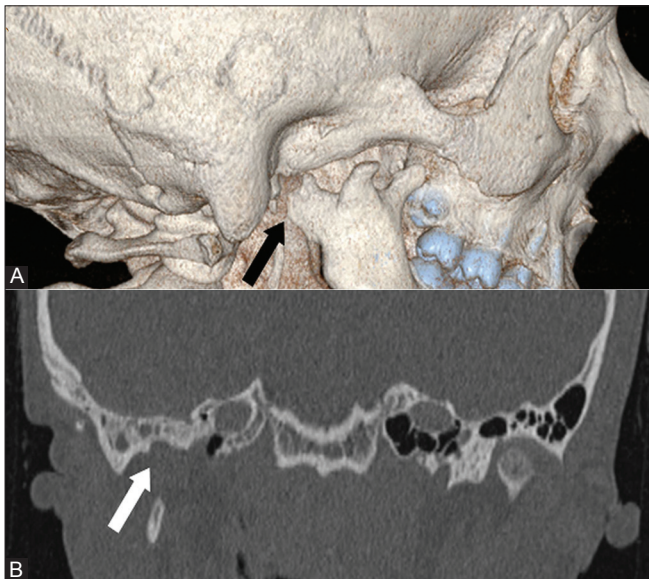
(A, B): Mandibular condyle anomaly. (A) Volume rendered image shows bifid right mandibular condyle (arrow). (B) Coronal HRCT section of same patient shows double temporal articular fossa on right side (arrow)
